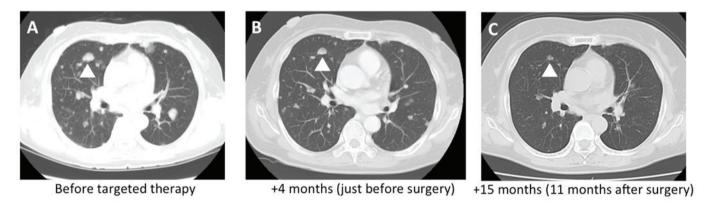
(A) Computed tomography revealed lung metastasis prior to the administration of axitinib. (B) The measurable metastatic pulmonary lesion (arrowheads) exhibited a 1% increase in size at 4 months after the initiation of axitinib (just prior to surgery). (C) The lesion showed a size reduction of 11% at 15 months after the initiation of axitinib (11 months after surgery).
